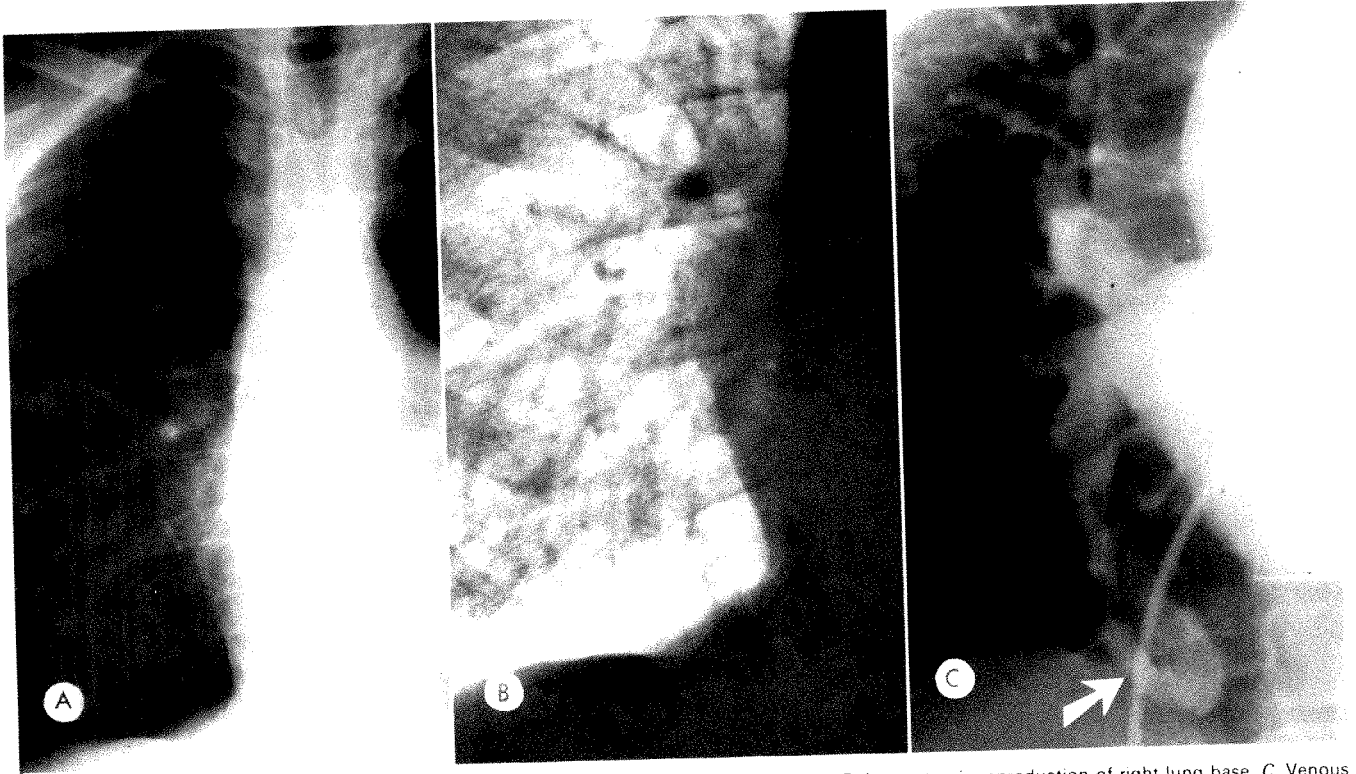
Case 2. *A*, Chest radiograph showing no evidence of unusual pulmonary densities. *B*, Log-e-tronic reproduction of right lung base. *C*, Venous phase of pulmonary angiogram of case 2 showing curvilinear varicose vein (arrow) draining medial basal segment of right lower lobe.
